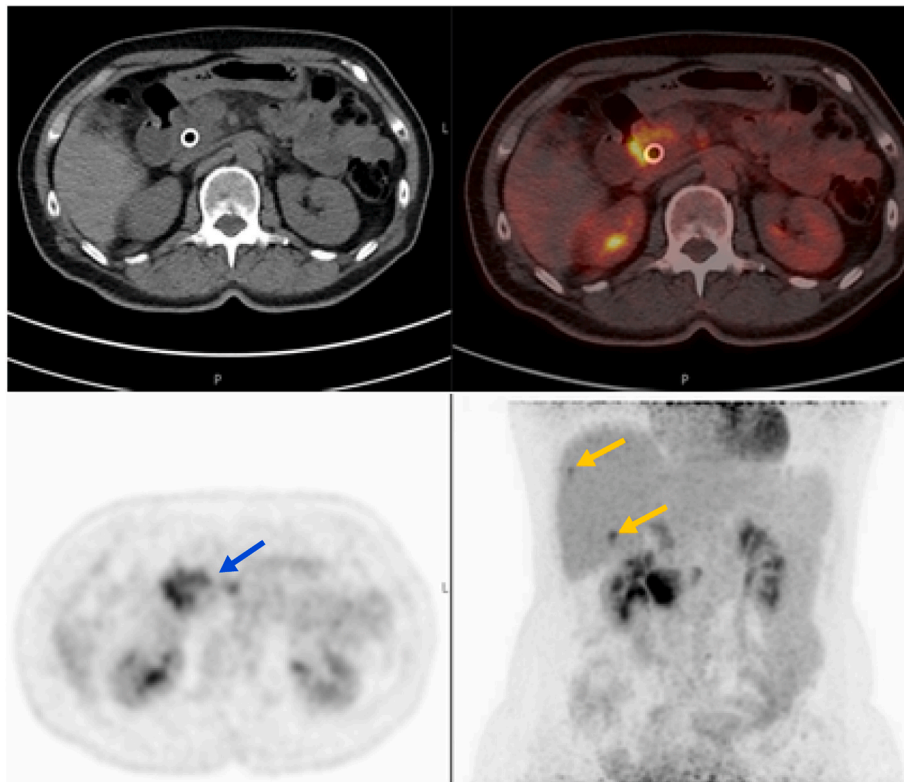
Four panel FDG-PET₁ image with low dose CT. Upper left: stent in the common bile duct. Lower left: intense uptake in the pancreatic head (blue arrow) and a positive lymph node retro pancreatic. Upper right: fusion image. Lower right: MIP projection showing the pancreatic lesion, the retro pancreatic node as well as two liver metastases (yellow arrows) which were not detected on ceCT.
